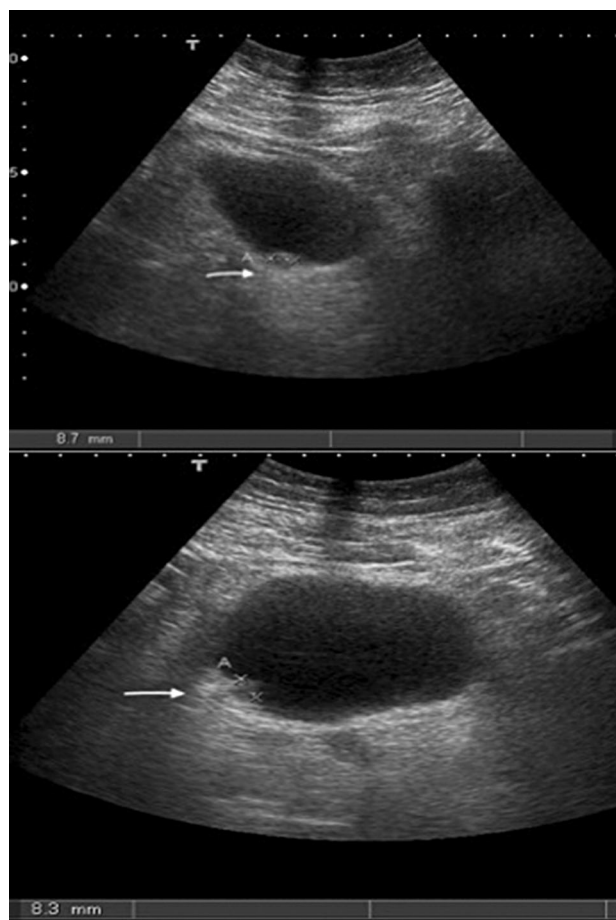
Abdominal ultrasound: intracavitary 8-mm nodule in the lateral right side of the posterior wall of the bladder.
